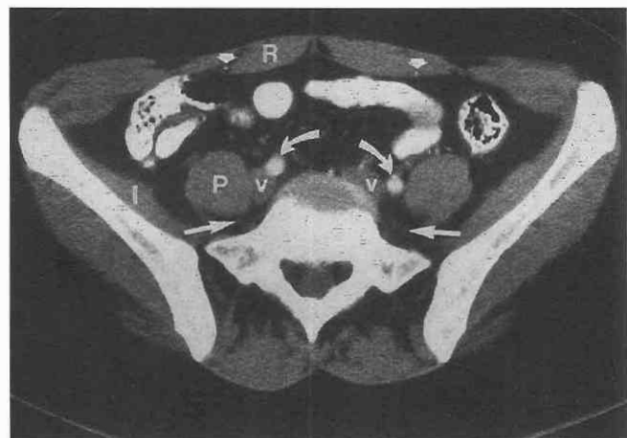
Normal anatomy. CT scan through contrast-filled ascending and descending colon in the iliac fossae shows the paired rectus abdominis (R), psoas (P), and iliacus (I) muscles. The common iliac arteries (curved arrows), common iliac veins (v), and lumbosacral trunks (straight arrows) are located anterior to the ala of the sacrum. The inferior epigastric arteries (arrowheads) are related to the posterior rectus muscles.
